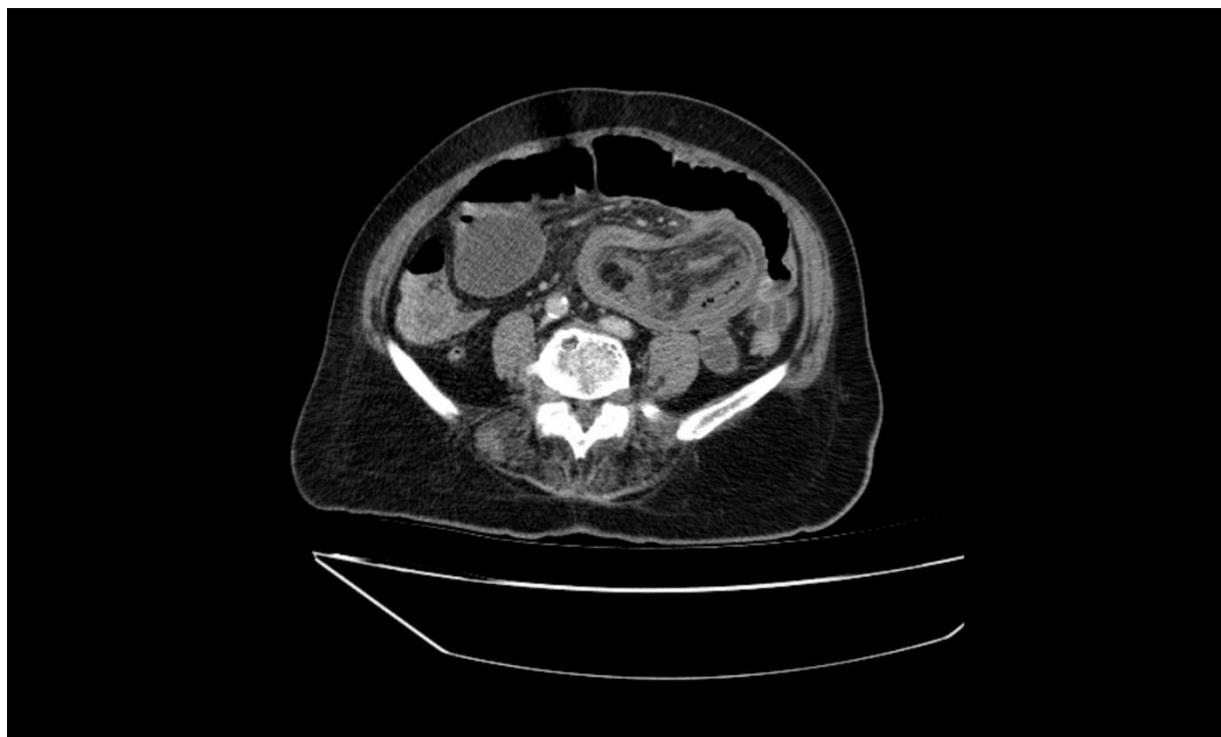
Donut sign shape in CT scan with intussusception
